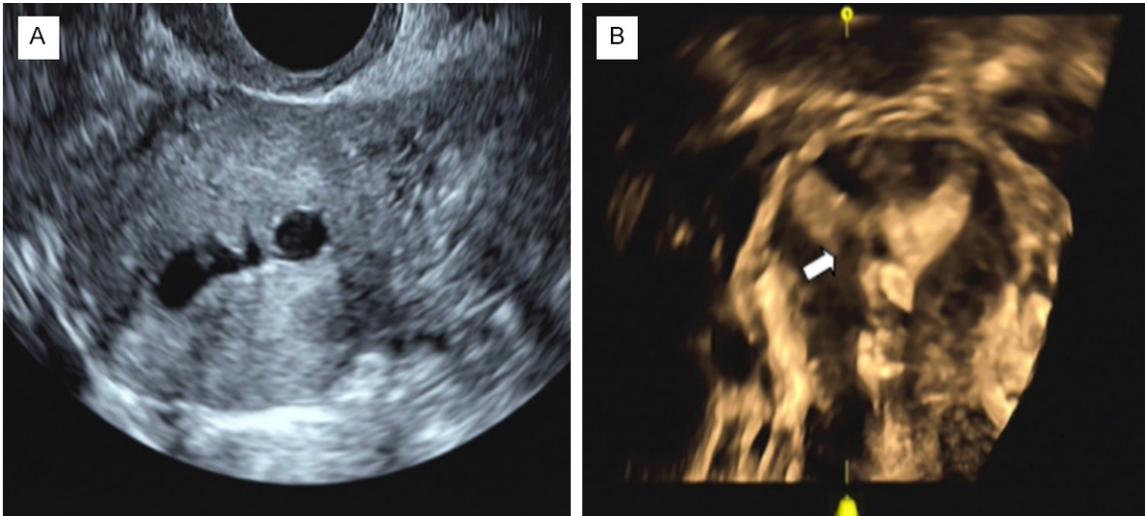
Two-dimensional ultrasound shows the discontinuity of endometrial cross-section, uterine cavity separation, uterine effusion, and intrauterine adhesion (A). Three-dimensional imaging shows filling defects of the endometrium (B).
